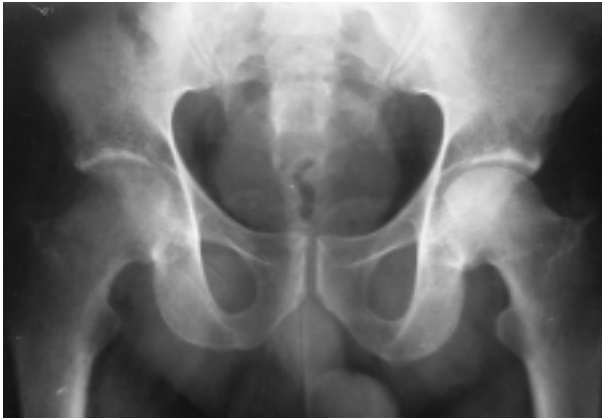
Anteroposterior xray of both hips in a 35-year-old male patient demonstrating severe osteopenia of the right femoral head and neck. This was the first episode of an RMO.
